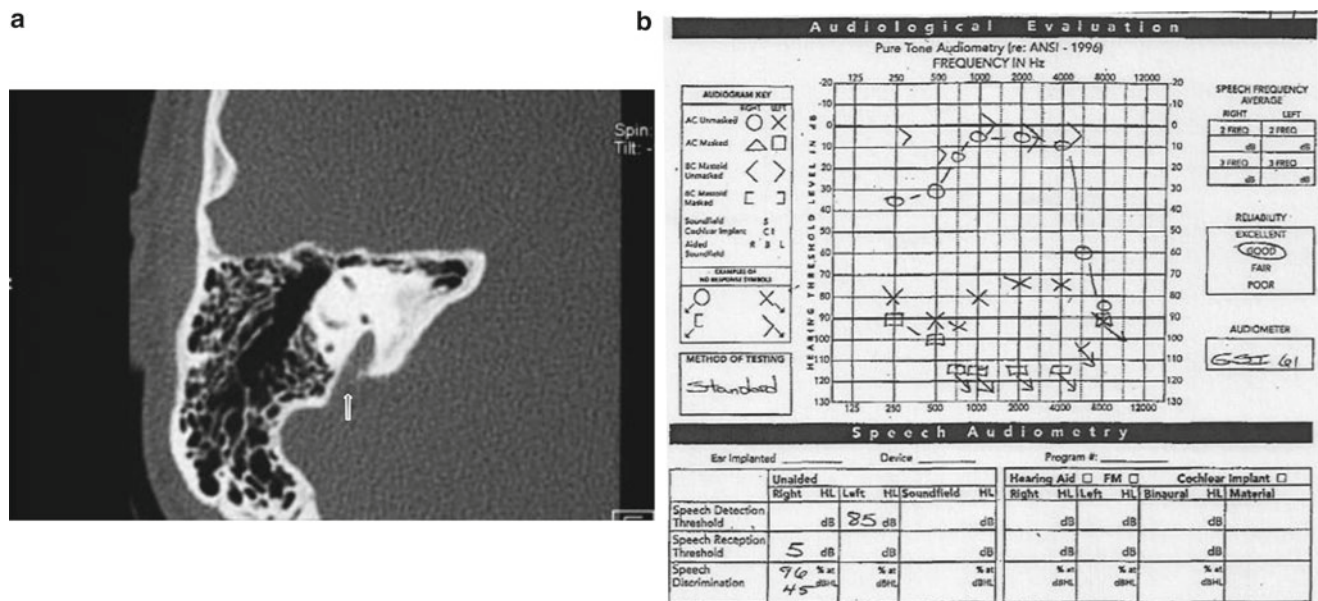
(a) CT temporal bone axial section of right ear demonstrating wide vestibular aqueduct (arrow). This finding was present in both ears of this 10-year-old with a history of progressive unilateral hearing
